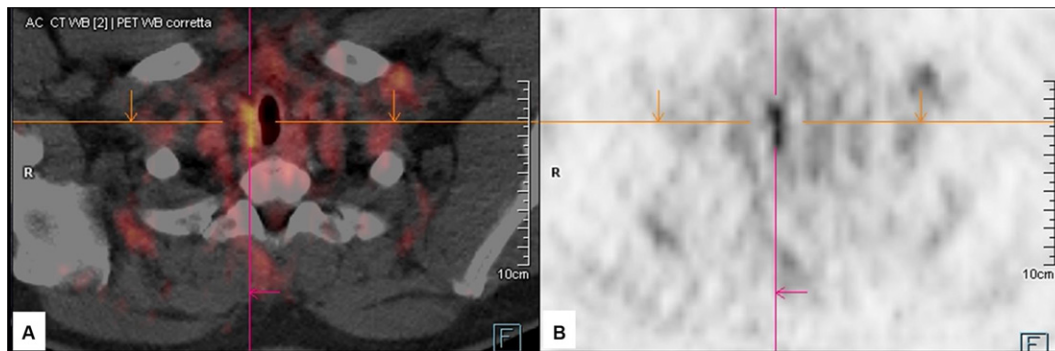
Axial ^{18}F -FDG PET/CT (A) and PET (B) images in a differentiated thyroid carcinoma patient with increasing serum thyroglobulin levels after thyroidectomy and negative radioiodine whole-body scan. PET/CT showed an area of increased radiopharmaceutical uptake corresponding to a tissue located in the right thyroid bed and corresponding to DTC relapse.
